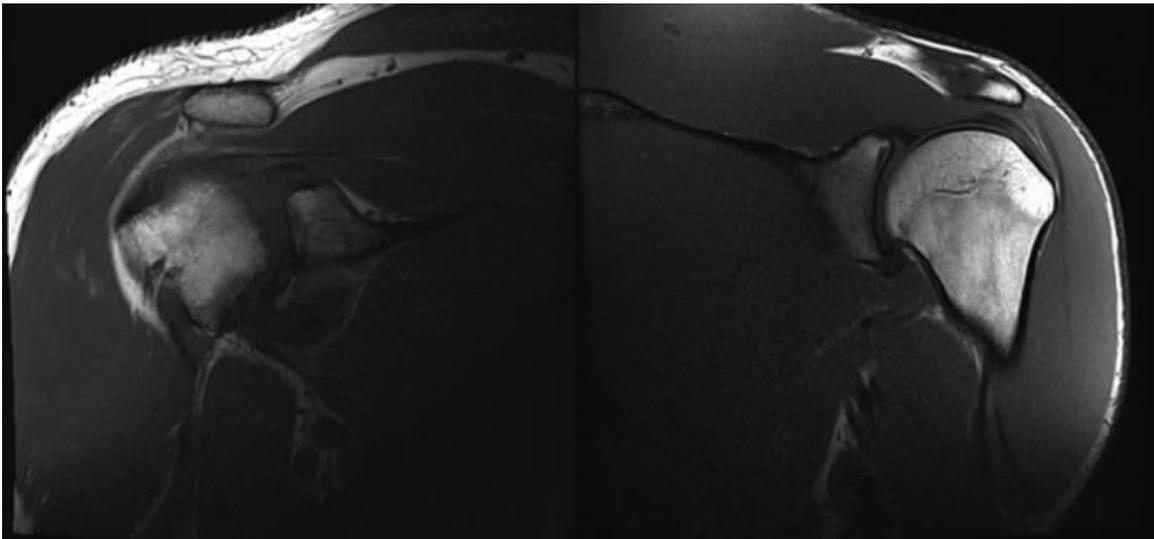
Coronal T1-weighted image - The rotator cuff muscles are markedly hypertrophied, bulky, with complete loss of intramuscular fat. Resultant indentation of the myotendinous junction by the acromion and effacement of the infra-acromial fat
